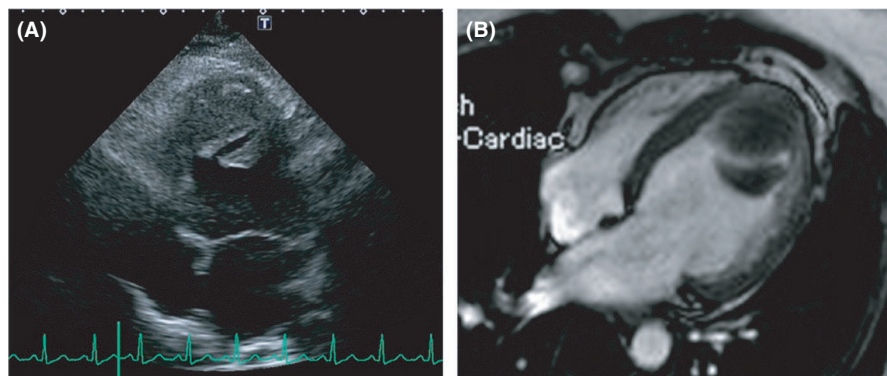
Transthoracic echocardiography (A) and magnetic resonance imaging (B) showed a pedunculated mobile and a laminated mural thrombi in the left ventricle
